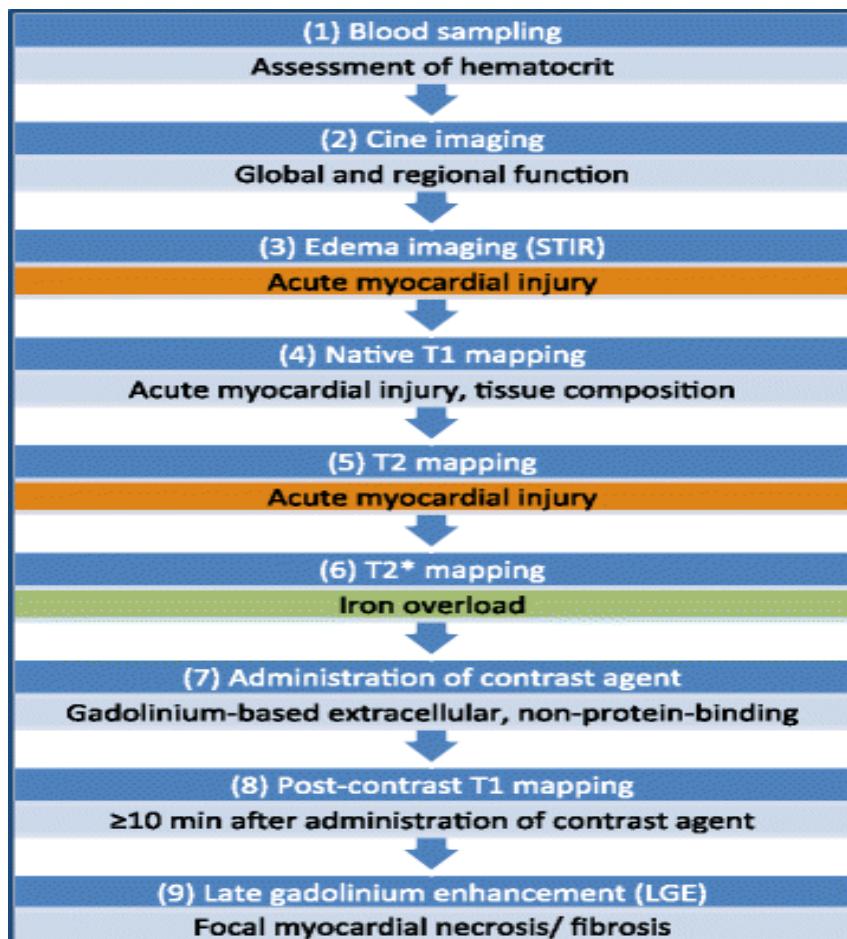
The recommended protocol for cardiac MRI and parametric mapping
